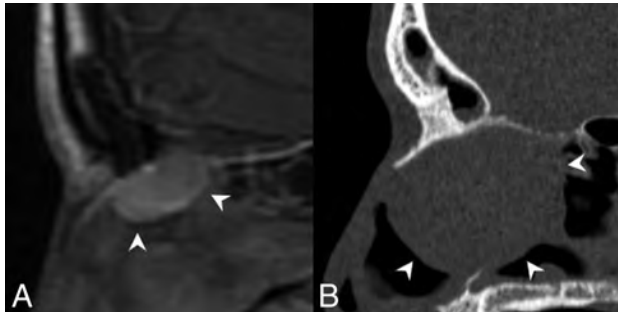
Crescent sign. A, Sagittal T1 postcontrast MR image of an REAH. B, Sagittal noncontrast CT image of a seromucinous hamartoma demonstrates a characteristic half-moon morphology (*white arrowheads*), which we have termed a “crescent sign” when the lesions arise in the olfactory recess.
